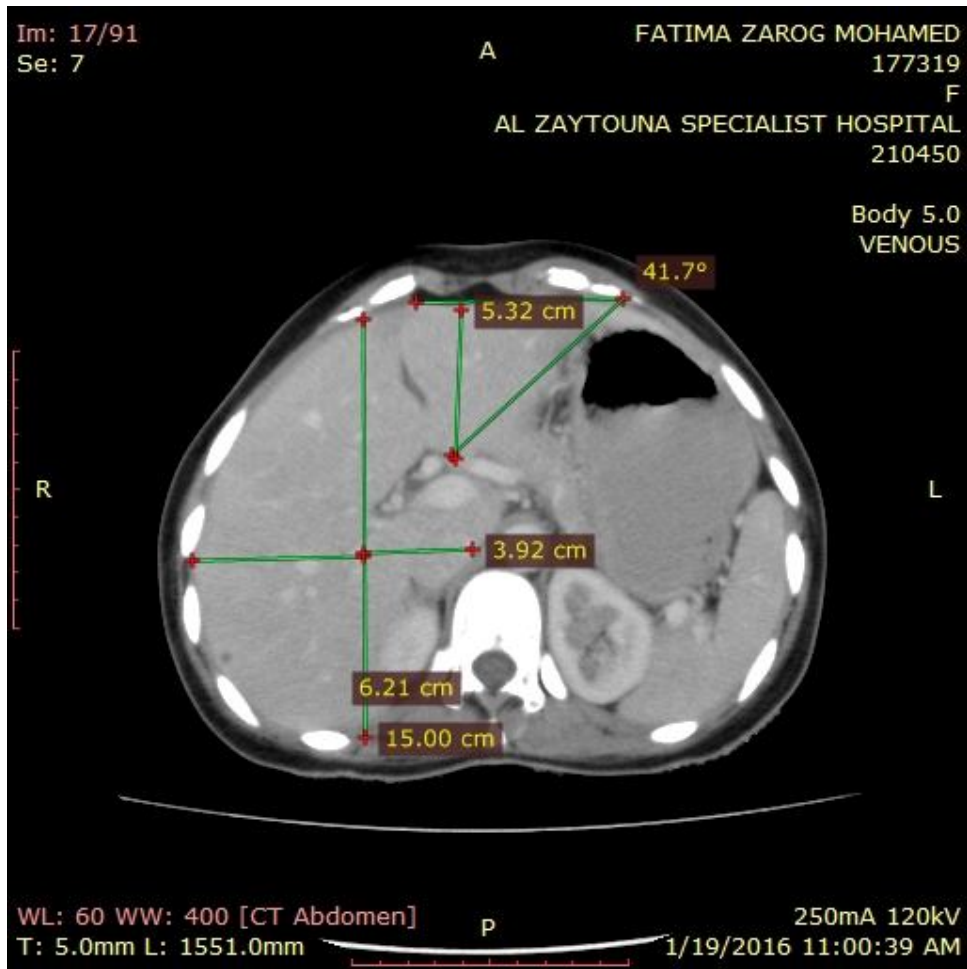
Fig CT liver axial venous phase the left hepatic angle -41.7° AP diameter of the left hepatic lobe 5.32 cm diameter of the right lobe -6.21 cm diameter of the caudate lobe -3.92 cm
